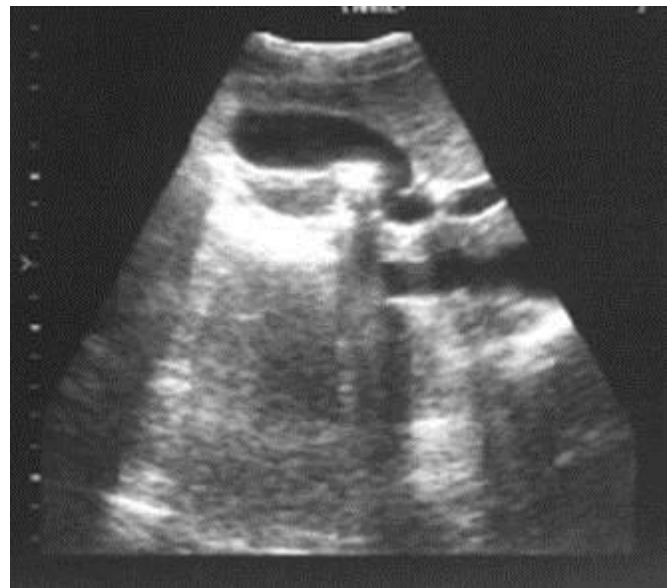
Ultrasound image of the gallbladder with flexion in the portion of the neck.
